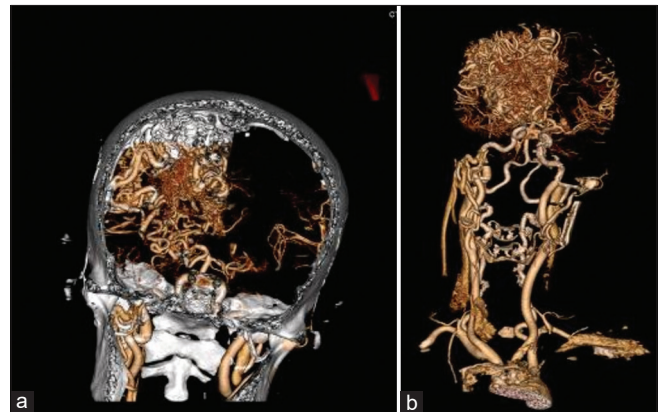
(a) Head-and-neck computed tomography angiography (CTA), Volume rendering, coronal section (a): In the right frontoparietal lobes, pathological conglomerations of abnormal blood vessels like arteriovenous malformation is present, whereas feeders go from the right middle cerebral artery a drainage system goes through the magistral cortical veins in superior sagittal sinus. (b) Head-and-neck CTA, Volume rendering, anteroposterior projection (b): In the right frontoparietal lobes, arterio-venous malformation is present, whereas feeders go from the right middle cerebral artery, a drainage system goes through the magistral cortical veins in the superior sagittal sinus
